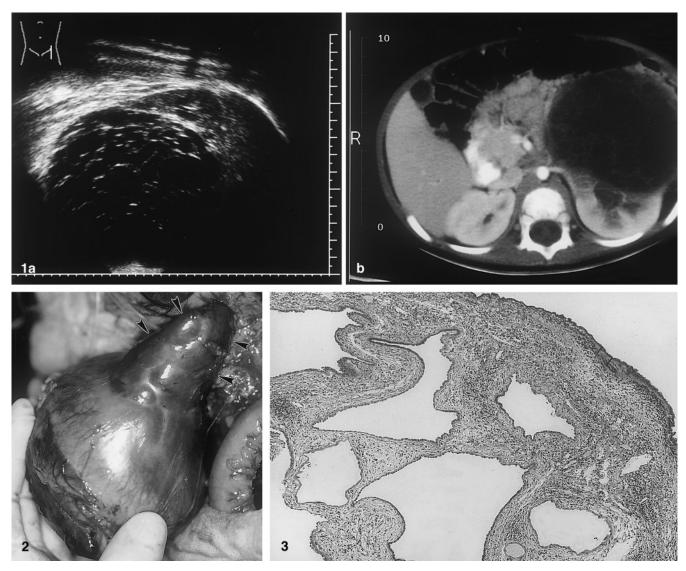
a US scan of left kidney demonstrating multicystic tumor of lower pole. b CT scan showing cystic tumor of left kidney with thin septa without solid tumor
